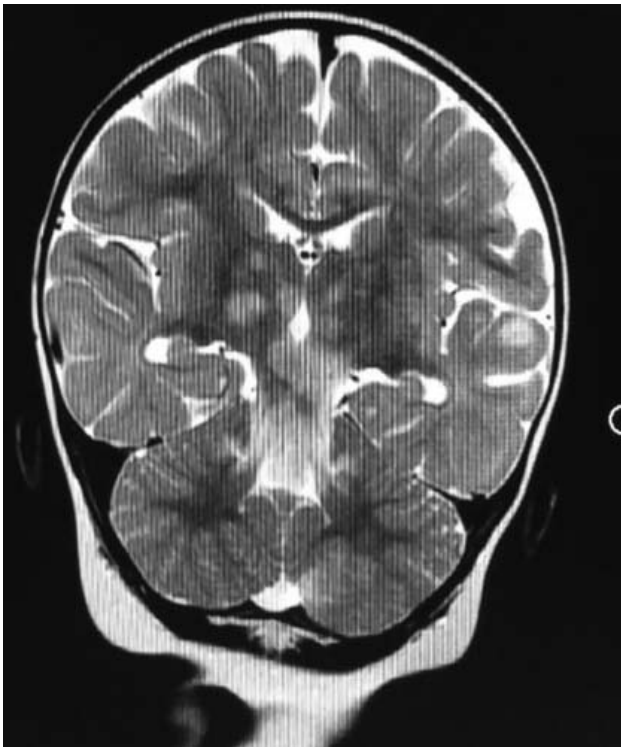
MRI Brain showing T2/ FLAIR hyper intense signals bilaterally, involving bilateral thalami, basal ganglia, grey white matter junction and cerebellar hemispheres.
